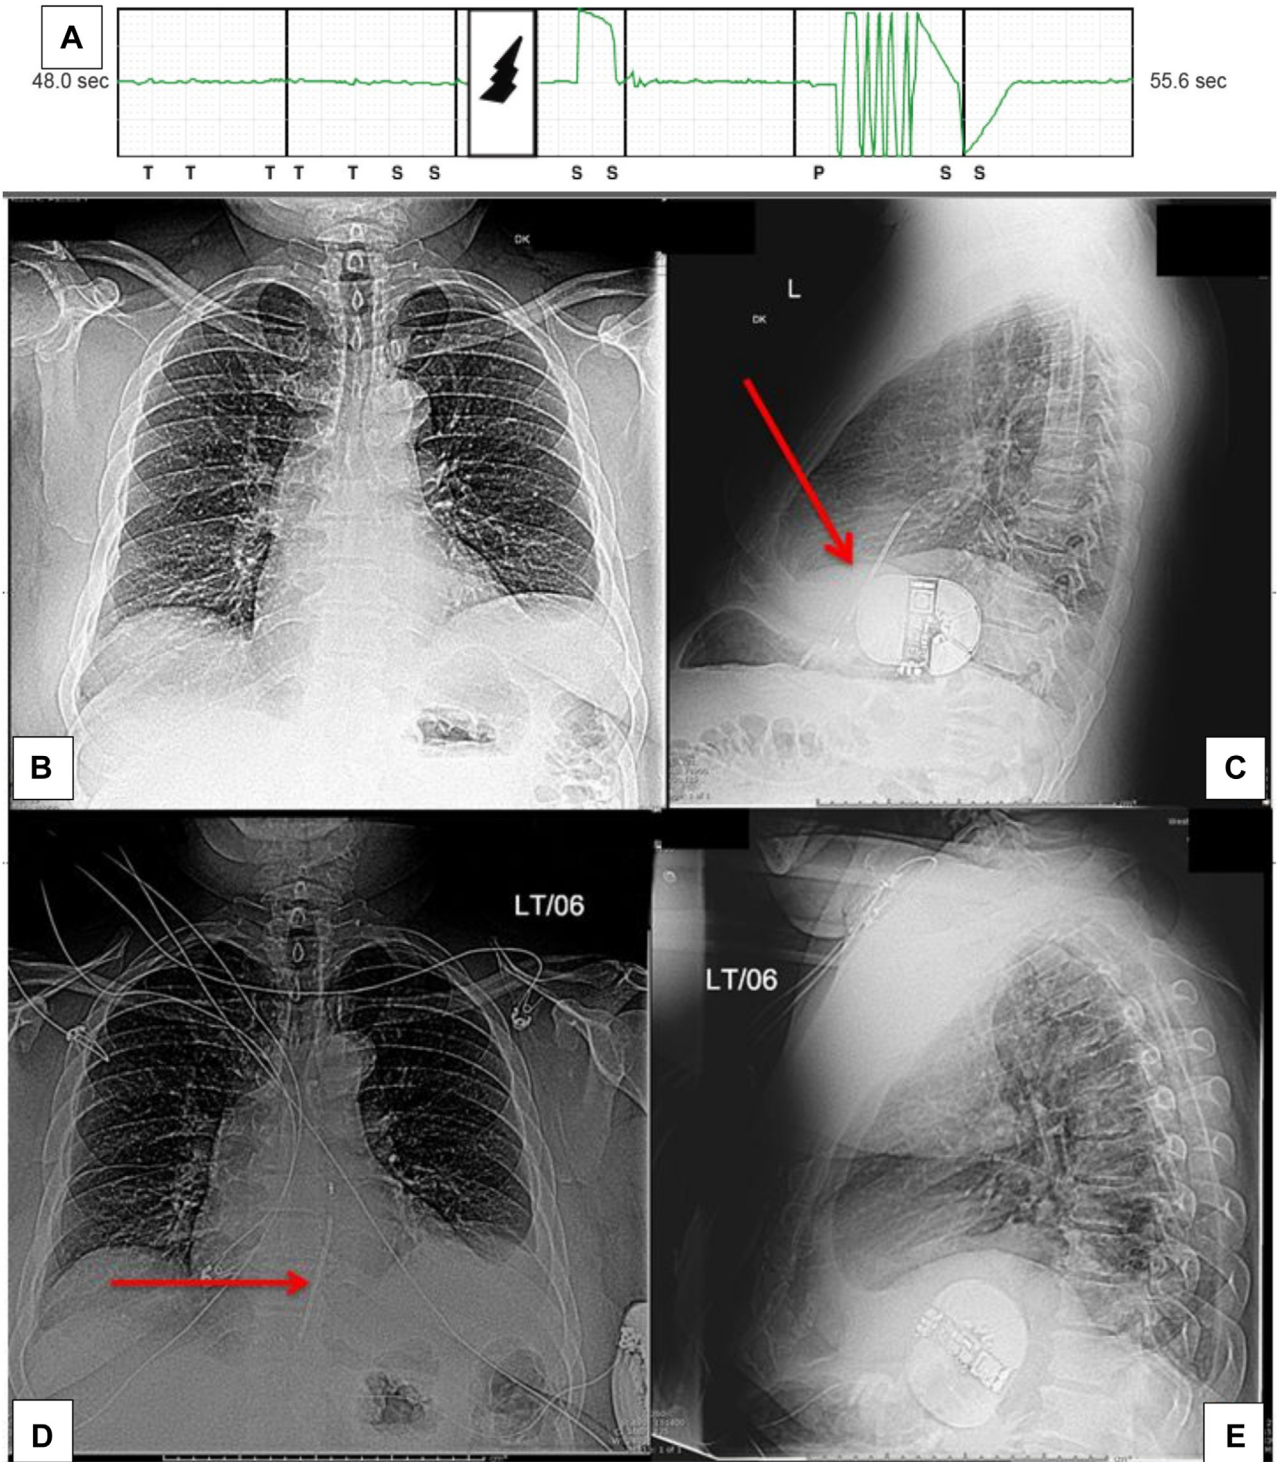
A: Electrogram showing inappropriate shock. B, C: Anterior-posterior/lateral chest radiographs showing lead dislodgement. D, E: Anterior-posterior/lateral chest radiographs after initial implantation. Red arrows indicate lead tip. Note difference of pulse generator orientation in pocket compared to original implant.
